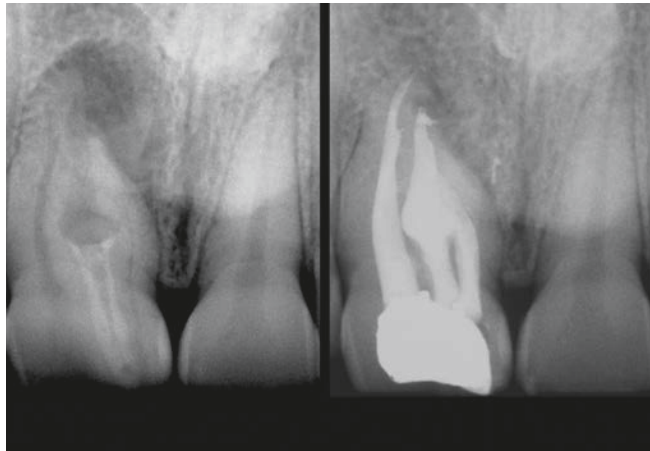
Left: A radiograph of the maxillary right central incisor suggests dens in dente, internal resorption, multiple canals, and a large asymmetrical lesion. Right: A 6-month recall reveals multiple filled systems and progressive apical and lateral osseous repair (courtesy of Dr. Francesco Mangani; Rome, Italy).
